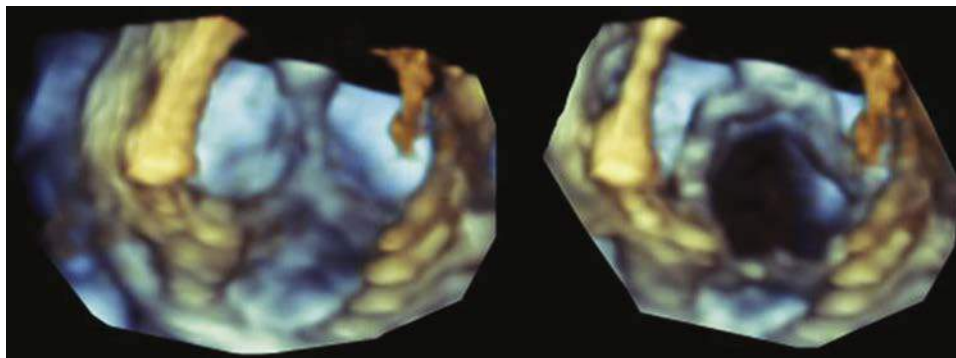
Three-dimensional echocardiogram imaging of a biological pulmonary valve a few days after surgical implantation in a 37-year-old male born with tetralogy of Fallot. After several surgical procedures, he developed severe right ventricular (RV) dilatation, free pulmonary regurgitation, and a large calcified aneurysm of the RV outflow tract (see also Fig. 11.4).
